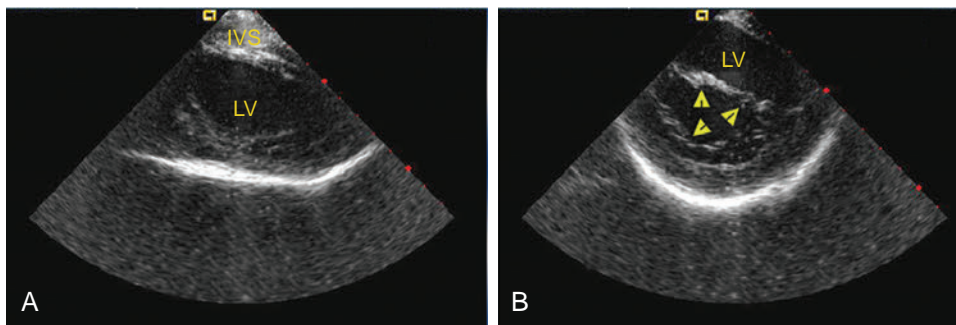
Intracardiac Echocardiographic Images of the Left Ventricle (LV). The transducer is placed in the right ventricle against the interventricular septum (IVS). (A) Long-axis view of the LV. (B) Short-axis view of the LV at the level of the mitral valve (arrowheads).
